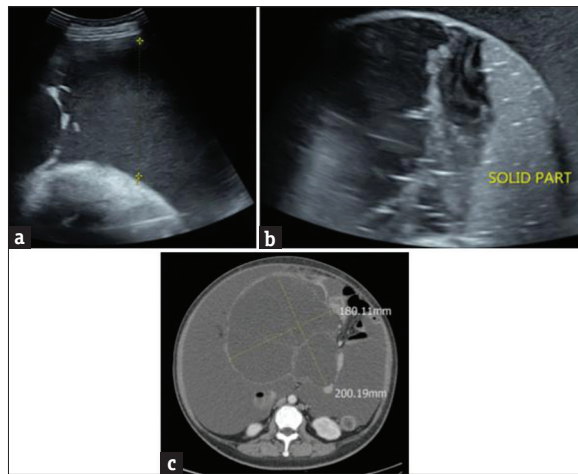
Ultrasonography reveals massive ascites (a) and a 16 cm × 12 cm multiseptated ovarian tumor with a solid component (b). (c) Computed tomography of the abdomen and pelvis displays an ovarian mass about 20 cm × 18 cm
